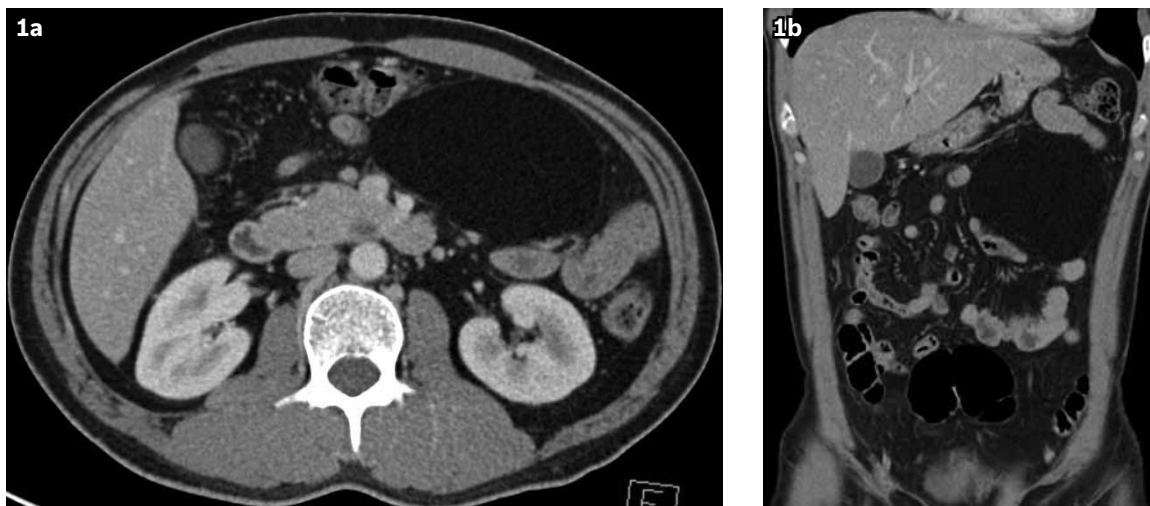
(a) Axial and (b) coronal CT images show a well-defined, encapsulated fatty lesion in the small bowel mesentery, which was pathologically proven as a benign lipoma.
